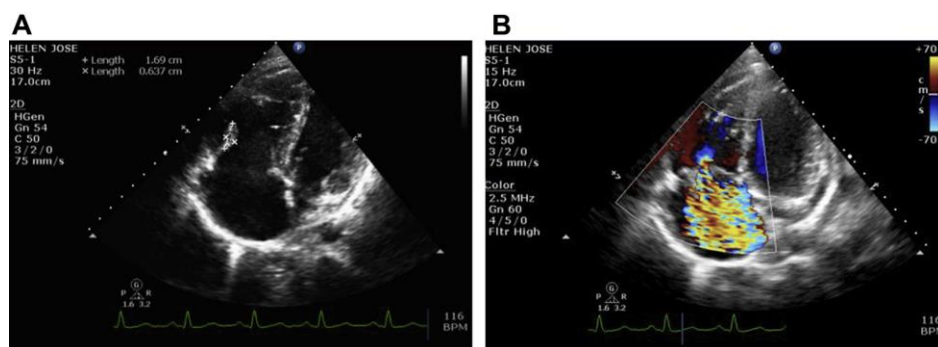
(A, B) Echocardiographic image: HIV-positive, cART-naïve, intravenous drug user showing a large vegetation on tricuspid valve (A) caused by *Staphylococcus aureus*, complicated by severe tricuspid insufficiency (B).
